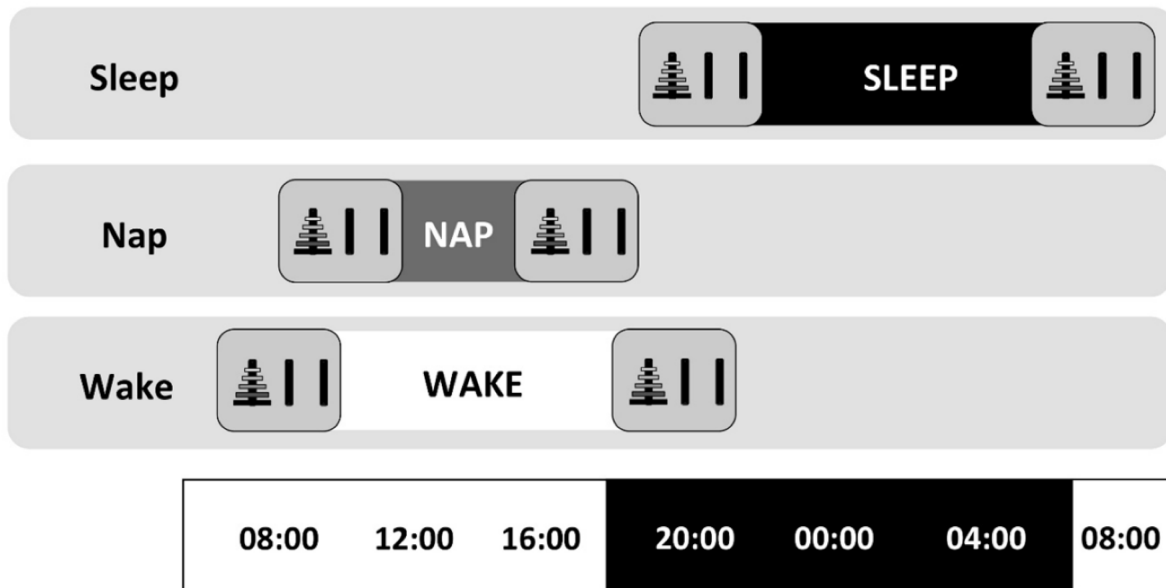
Overview of experimental protocol in the Sleep, Nap and Wake conditions. Sleep Condition: Participants arrived at the laboratory at approximately 08:00 PM, were trained on the classic ToH, and performed the CTL task. Participants then slept in the lab from approximately 11:00 PM to 07:00 AM while their sleep was recorded via PSG. Upon awakening, participants were retested on the ToH and performed the CTL task. Nap Condition: Participants arrived at the lab at approximately 10:30 AM, were trained on the ToH and performed the CTL task, and slept in the lab from approximately 01:00 PM to 02:30 PM while their sleep was recorded via PSG. Upon awakening, participants were retested on the ToH and performed the CTL task. Wake Condition: Participants arrived at the lab at 08:00 AM and were trained on the ToH and performed the CTL task. Participants then left the lab for the day with instructions not to nap (confirmed via actigraphy). Participants returned to the lab at 08:00 PM and were retested on the ToH and performed the CTL task. All sessions of the ToH and CTL tasks were completed while obtaining functional blood oxygen level dependent (BOLD) images using a block design (see section “*MRI Imaging Acquisition and Analysis*” for details). During the ToH testing and retesting sessions, participants performed a 5-disk version of the classic ToH task in addition to CTL task, to control for random motor movements (see section “*Behavioural Tasks and Analysis*” for details). The order of the ToH and CTL tasks was counterbalanced across participants.
